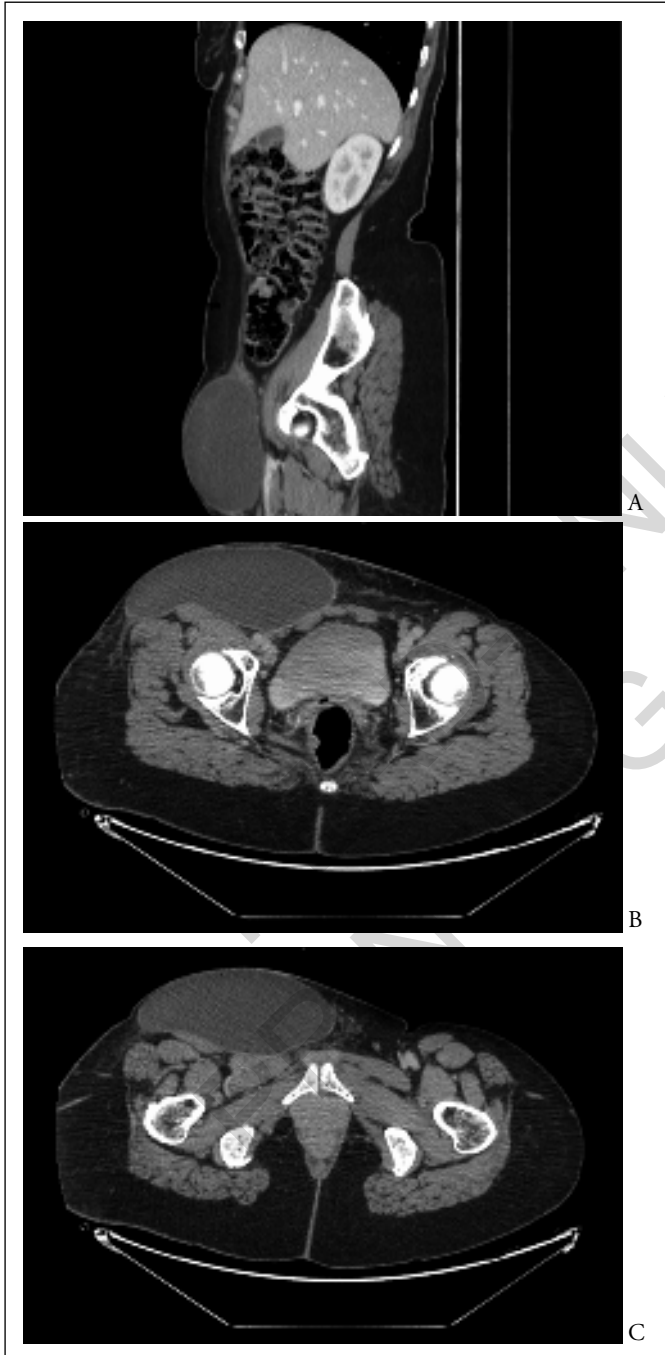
A,B,C) Preoperative CT scan demonstrates the presence of lymphocele located in the inguinal region.
